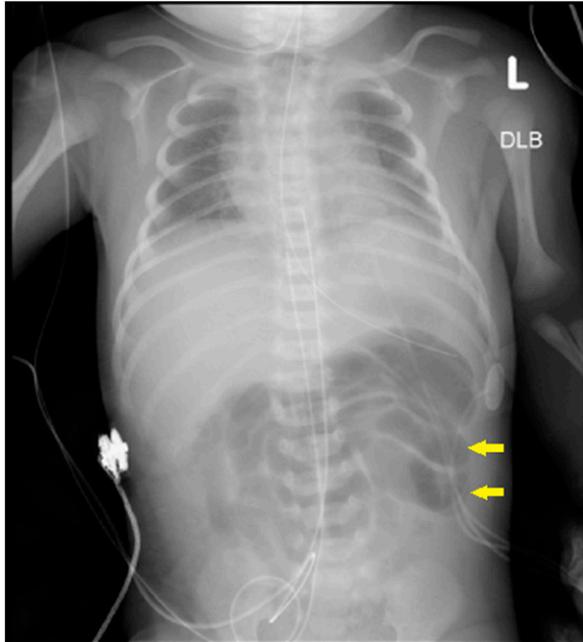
Abdominal radiograph demonstrating distended loops of bowel (yellow arrows).
